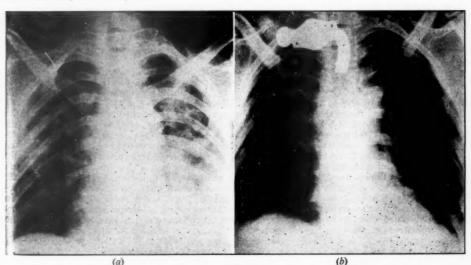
To show resolution of bronchopneumonia after tracheotomy. Radiographs taken (a) five days before tracheotomy, and (b) eight days after tracheotomy.
